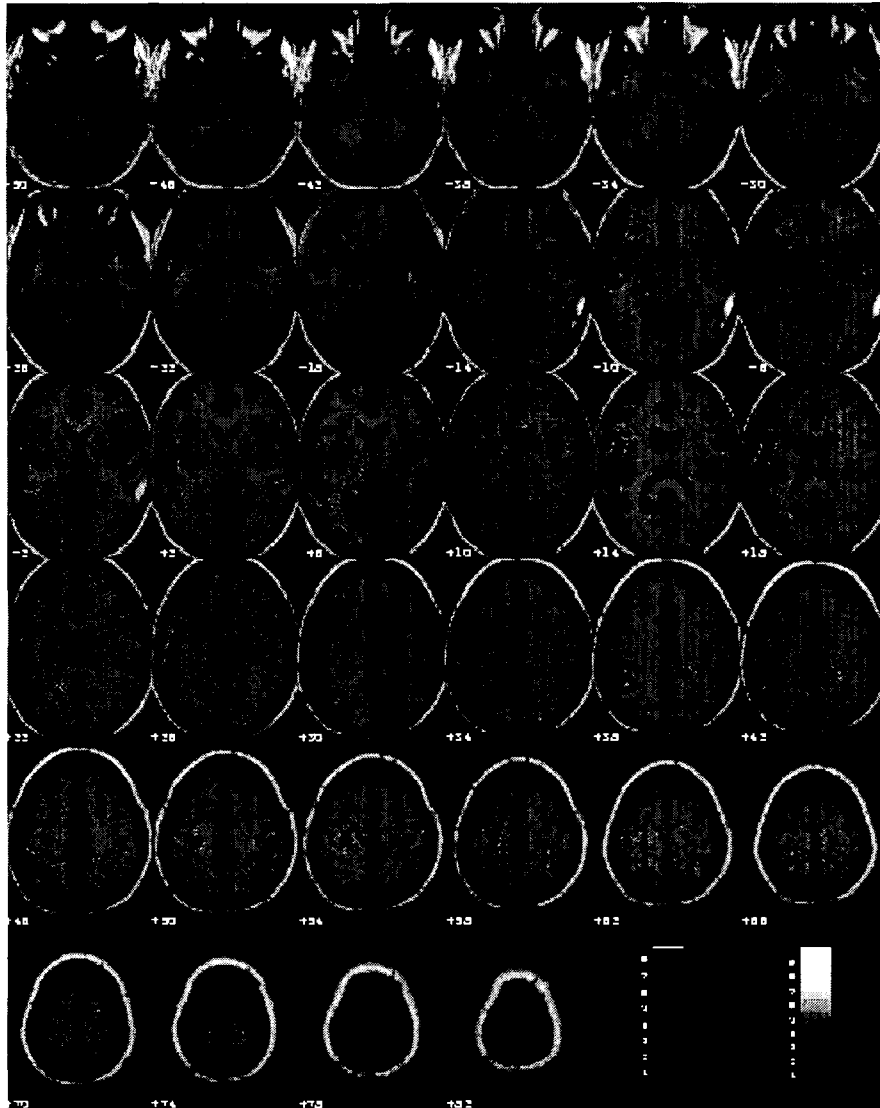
Fusion of SPM99 results to transverse template T1 weighted high-resolution brain MRI. Areas of increased (red) and decreased (blue) rCBF are noted in patients with TGA (n=8) compared with normal control (n=17).
